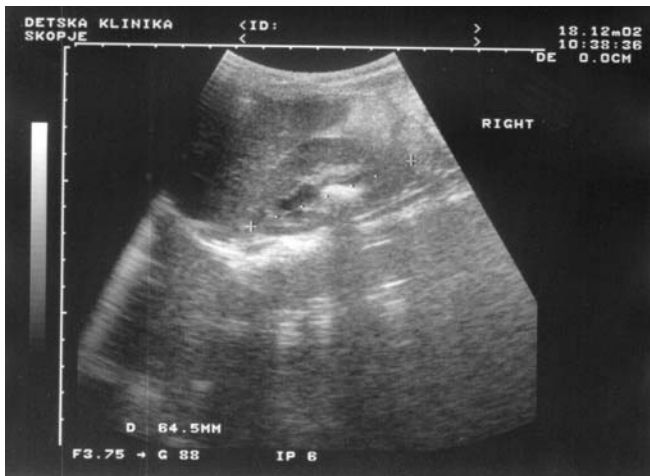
Ultrasound scan of the right kidney revealing a solitary calculus in the renal pelvis
